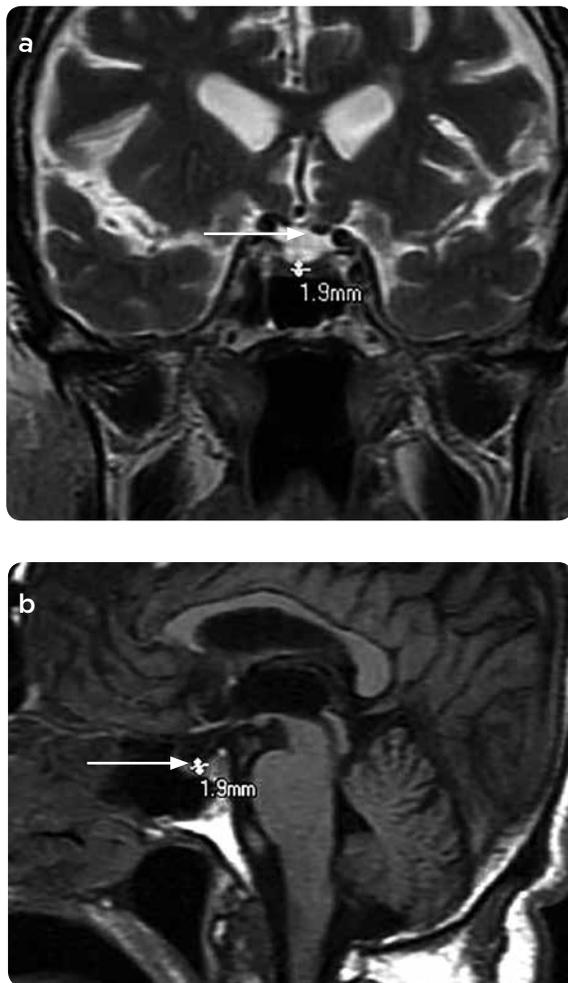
a) Cerebral MRI enhanced in T2, coronal, b) Cerebral MRI enhanced in T1, sagittal, of a 78 year old man evidencing complete ESS (pituitary height < 2 mm) and sealed space replaced by high signal CSF and significant changes in cortical atrophy (arrows).
